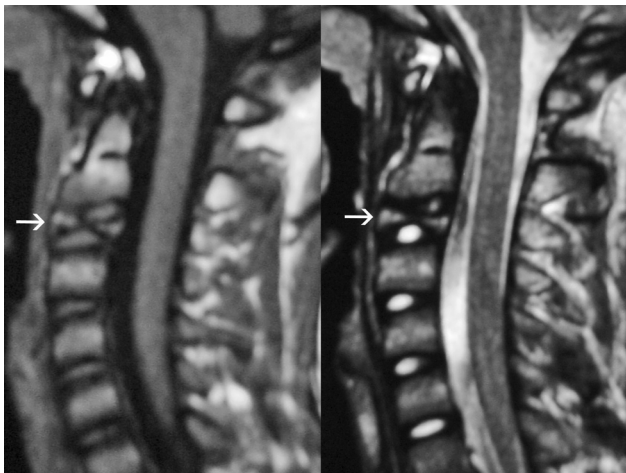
Cervical spine MRI in a 16-year-old boy with treated LCH (T1WI on the left; T2WI on the right), showing partial collapse of C3 (straight arrows), more pronounced centrally, yielding a biconcave configuration, with near-normal signal intensity following treatment. Note the preservation of the adjacent intervertebral discs.
